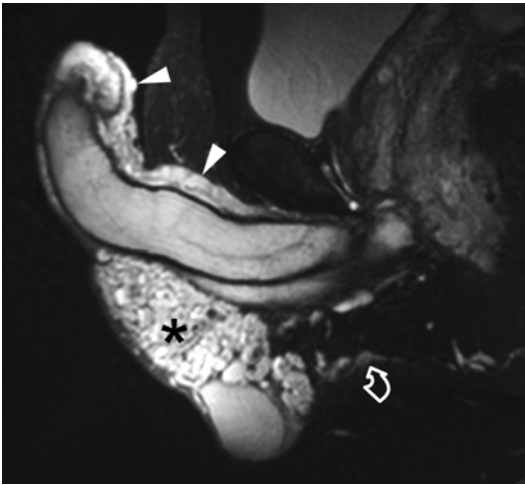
Giant penoscrotal cavernous hemangioma. T2-weighted sagittal MR image showing a high-signal-intensity lesion involving the scrotum (*asterisk*), the anterior portion of the perineum (*curved arrow*), and the dorsal aspect of the penis (*arrowheads*)
